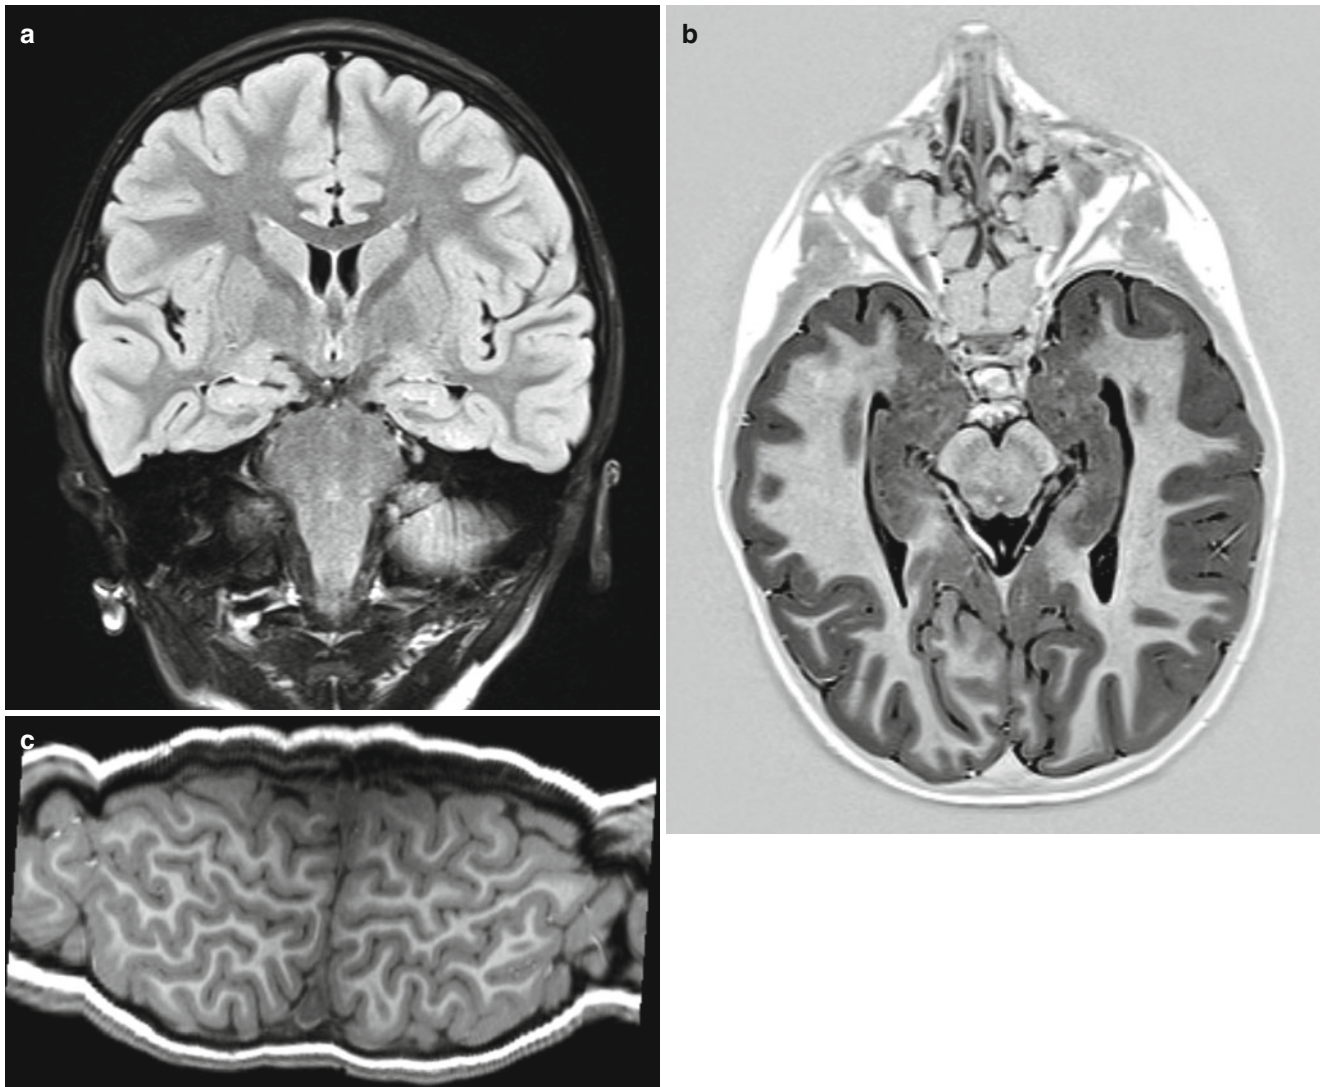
(a–c): Some examples of good sequences in a dedicated epilepsy protocol: (a) coronal T2/FLAIR, perpendicular to the hippocampal axis; (b) axial T1 inversion recovery (IR) parallel to the hippocampal
